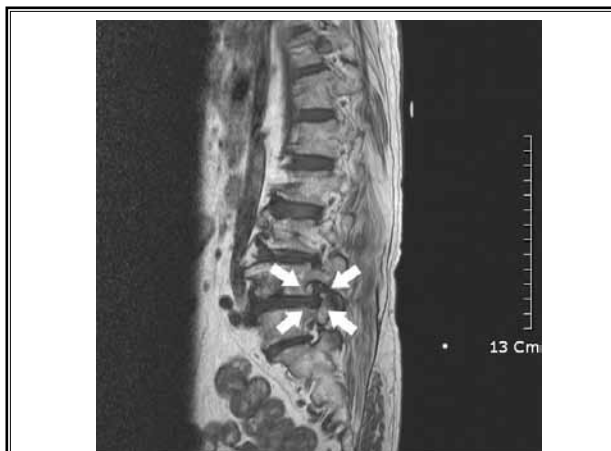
Grade 2 foraminal stenosis: T1-weighted sagittal image of 65-year-old man with right lower extremity pain shows narrowing of intervertebral disc space, thickened ligamentum flavum, and focal disk protrusion in foraminal zone due to perineural fat obliteration surrounding nerve (arrows).
